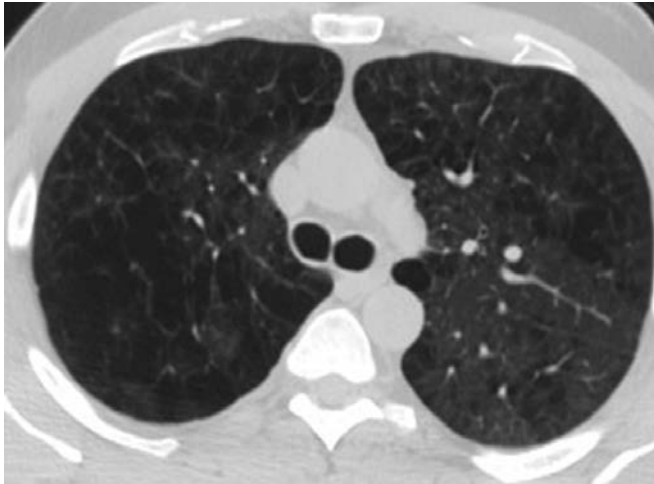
CT chest through the upper lobes showing focal areas of decreased attenuation. No definable walls are visible in these focal areas of hyperlucency. This patient was a smoker with centrilobular emphysema
